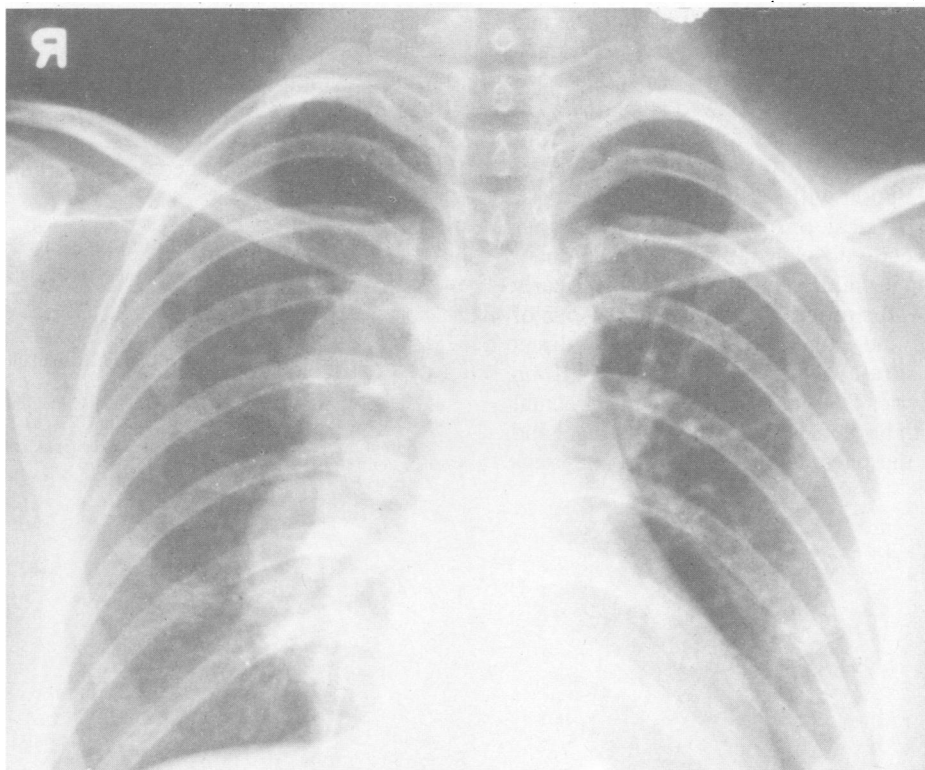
The posteroanterior chest x-ray film shows a well-circumscribed, smoothly margined, rounded consolidation projected over the right hilar area.
